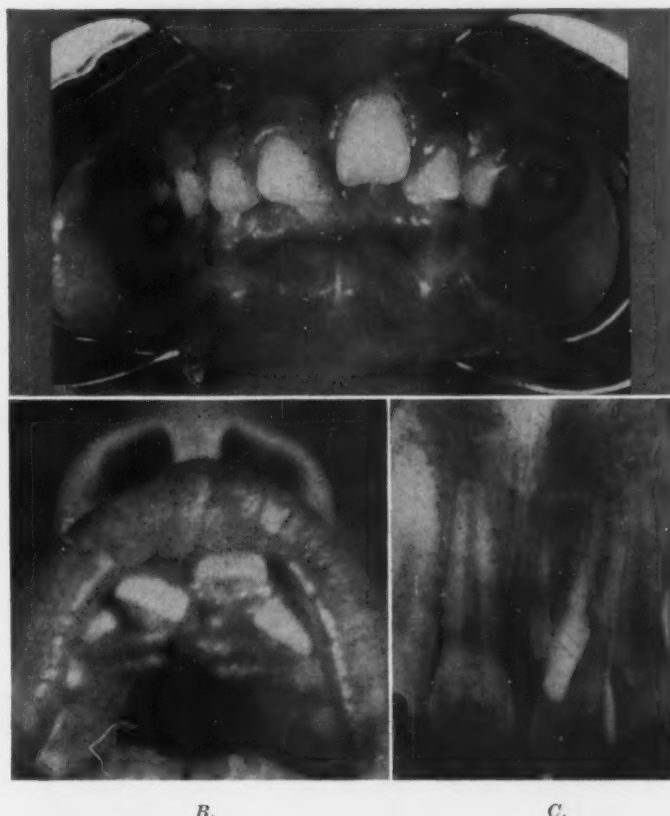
Intraoral and roentgenographic appearance of maxillary permanent right central incisor retarded in eruption following traumatization and devitalization of corresponding deciduous tooth.
